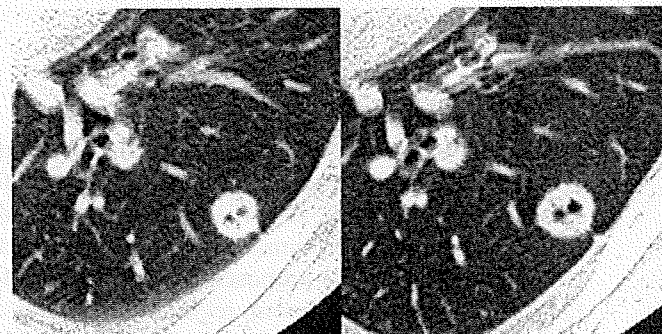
(Left: initial HRCT; right: last HRCT; type 3 radiological finding) 37-year-old male, never smoker, 6-month interval; adenocarcinoma with BAC features with wild type.
